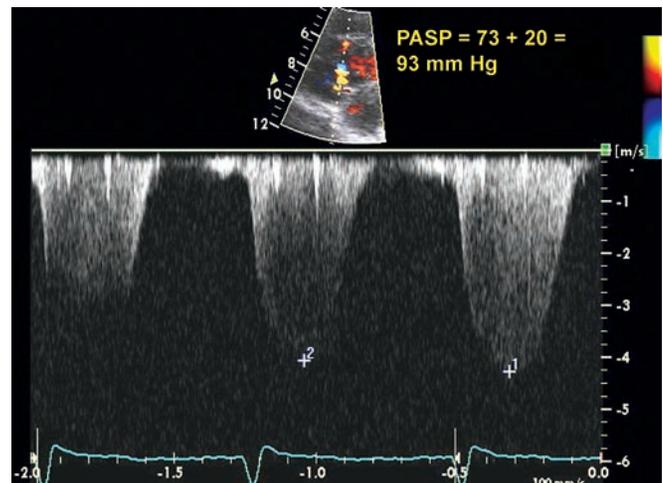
Follow-up transthoracic echocardiography. Continuous wave Doppler of tricuspid regurgitation. PASP = 93 mm Hg.
